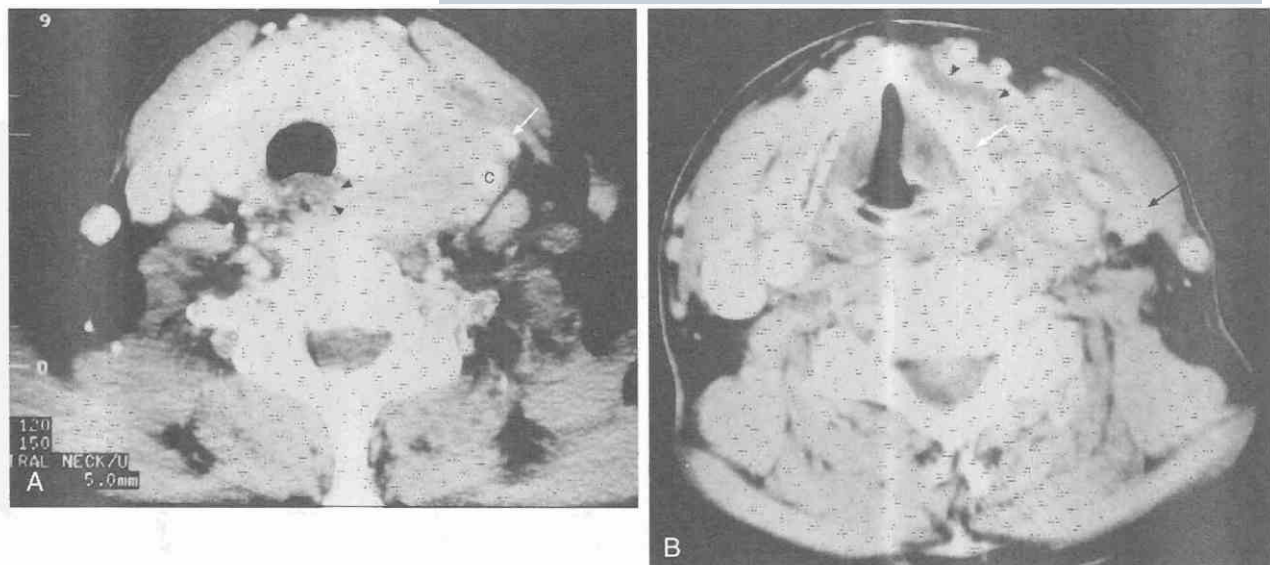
Anaplastic carcinoma. A, Axial postcontrast CT image shows an enhancing mass arising from the left thyroid lobe with invasion of the esophagus (*arrowheads*) and left carotid sheath. c, left common carotid artery; *arrow* indicates left internal jugular vein. B, CT scan of the same patient at the level of the true vocal cords shows the superior extent of the invasive tumor as it insinuates itself between the thyroid cartilage and the strap musculature (*arrowheads*). Invasion of the left thyroid ala has occurred (*white arrow*). An enhancing pathologic lymph node (*black arrow*) can be seen on the left, with spiculated margins indicative of extracapsular spread of tumor.
